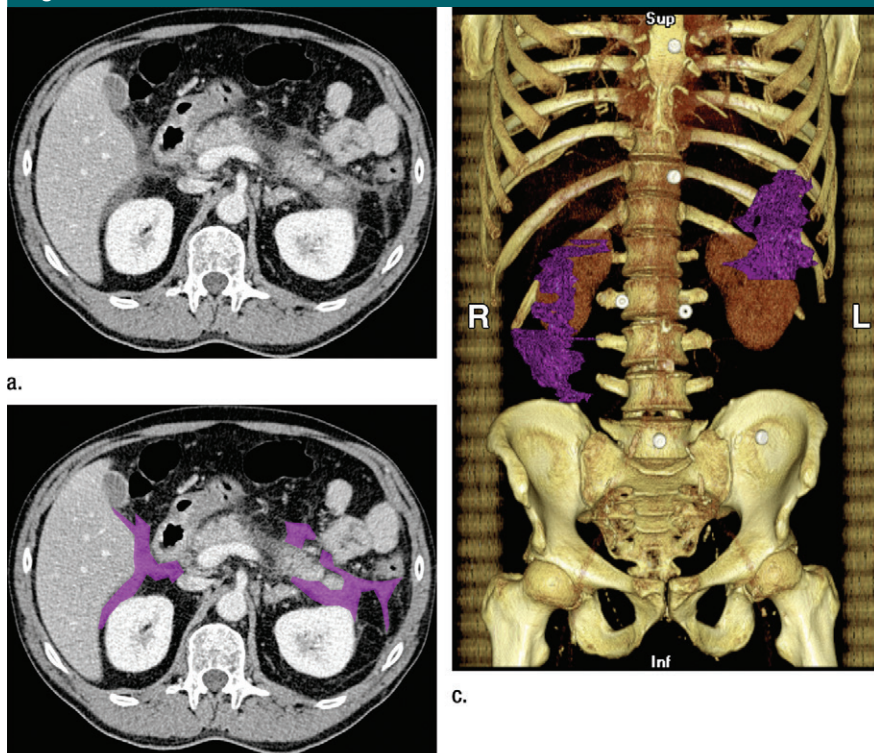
Images show grade E acute pancreatitis with only 80 mL of extrapancreatic necrosis (<100 mL) in a patient with no organ failure or infection at follow-up. (a, b) Axial reconstructions from a CT study show segmentation of extrapancreatic necrosis in purple. (c) Three-dimensional model produced from segmentation of extrapancreatic necrosis.
